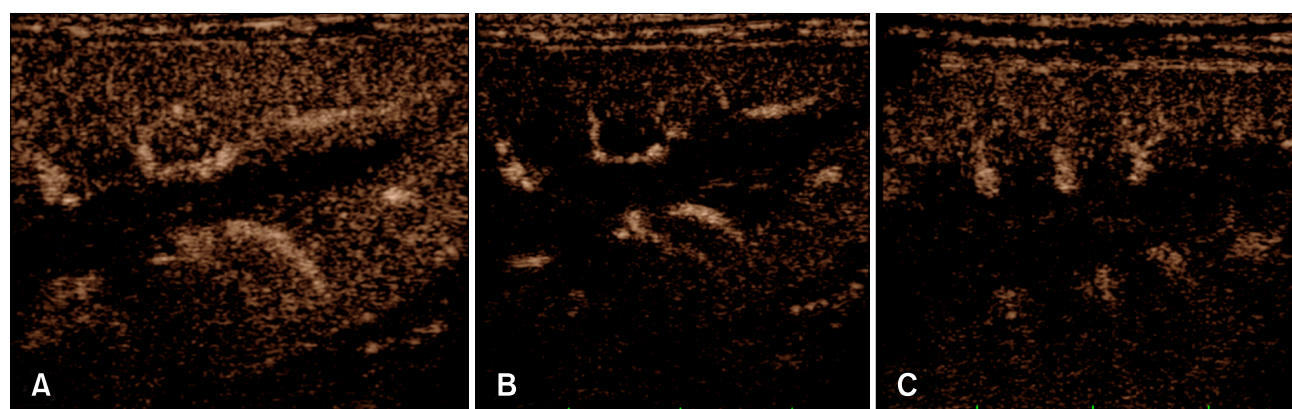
Contrast-enhanced ultrasonography images obtained at the time of peak intensity in the renal cortex at baseline (A), day 4 (B), and day 10 (C). At baseline, the renal cortex showed a homogeneous and intense enhancement pattern. At day 4, the renal cortex showed noticeably reduced contrast enhancement intensity. At day 10, there was increased intensity compared to that at day 4.
